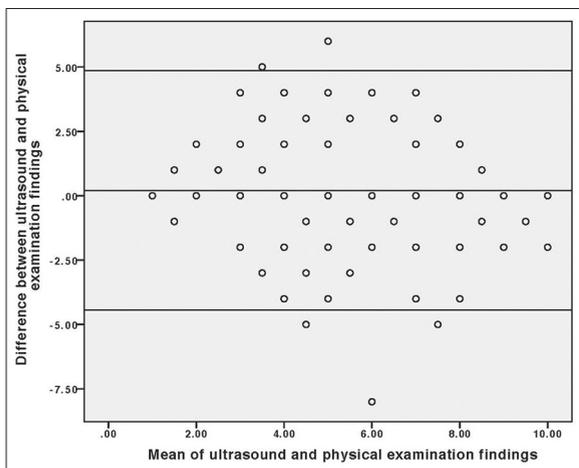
Bland–Altman Plot of correlation between point-of-care ultrasound and physical examination findings for estimation of intravascular volume. (The scatter in the plot demonstrates the frequently large differences in the estimations of intravascular volume, based on POCUS plus physical examination versus physical examination alone, for patients regardless of whether their intravascular volumes are low, normal, or high). X-axis: Mean of estimation of patient’s volume by (1) physical examination and (2) ultrasound plus physical examination. Y-axis: Difference between the estimation of patient’s volume by (1) physical examination and (2) ultrasound plus physical examination. Both axes are based on a visual scale of estimated intravascular volume status from 1 to 11. 6 = the patient was euvoalaemic. 1 = patient was severely hypovolaemic and 11 = severely volume overloaded.
